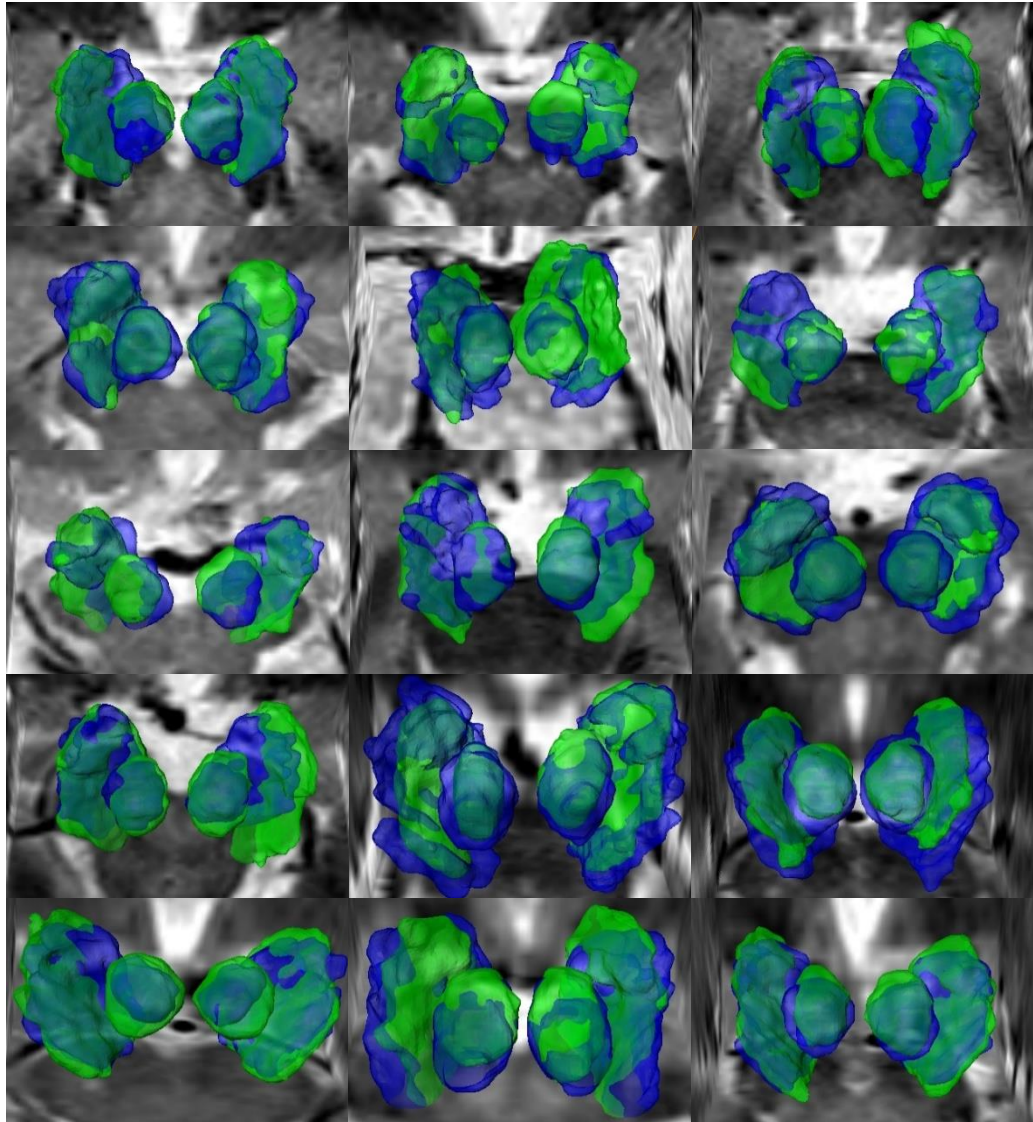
Visualization of automatically segmented predictors (green) - RN and a combined region of SN and STN - overlaid with their manual segmentations from the 7T MRI pairs (blue) on the axial plane of the 1.5T T₂W MRI from the 15 PD patients.
